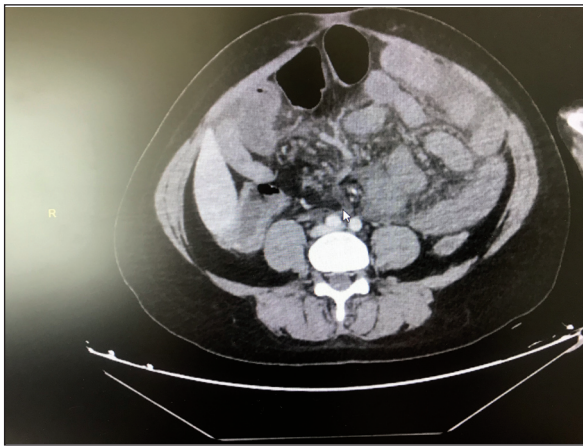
Computed Tomography of abdomen.
